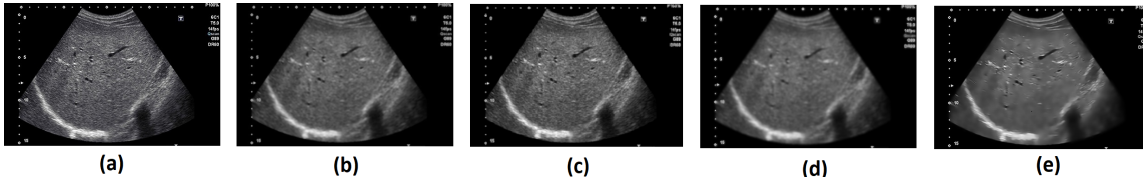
(a) Liver ultrasound image. De-speckling performance of (b) Frost, (c) Lee, (d) SRAD, (e) Proposed method.
